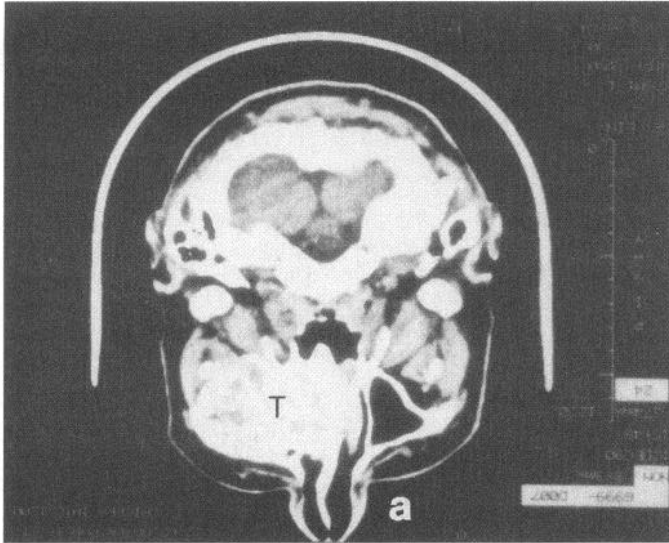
CT scan showing extensive effacement of left maxillary antrum by jaw tumor (T) in individual IV-1 in family 2. a, Anterior.
